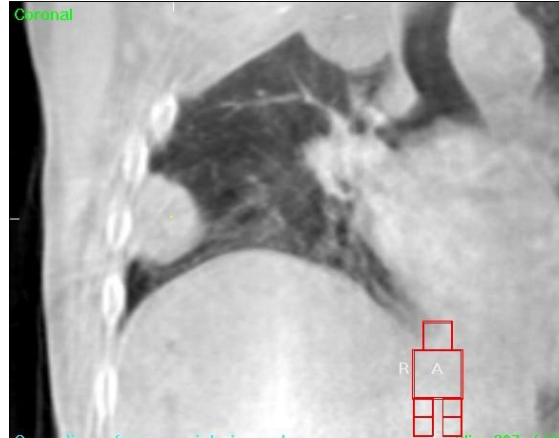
Image quality of in-room CT imaging
